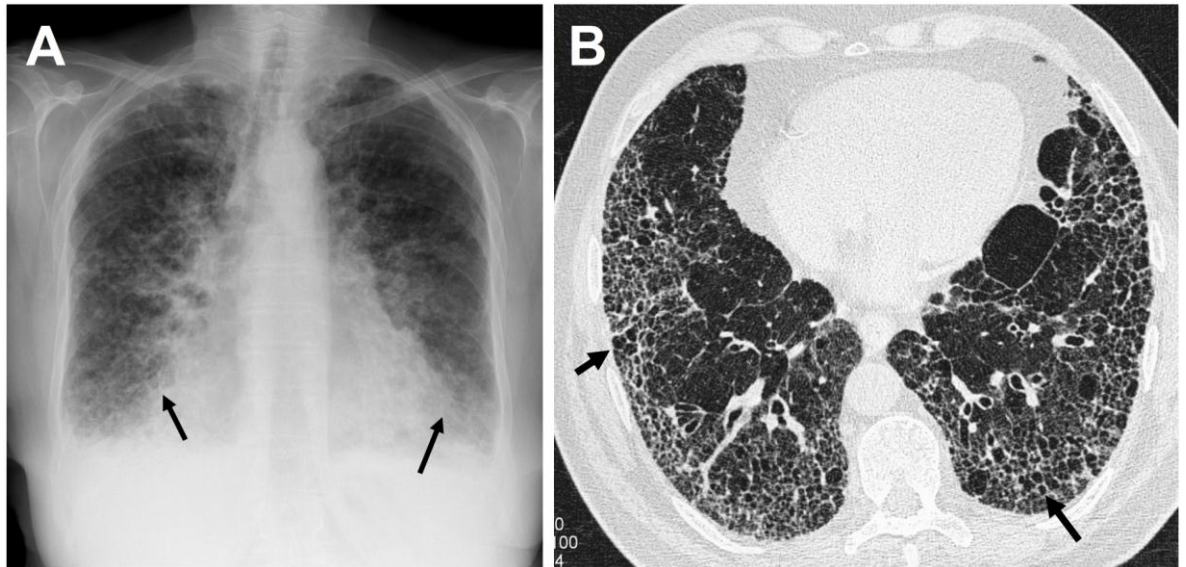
2: Chest radiographs of a patient with IPF.
